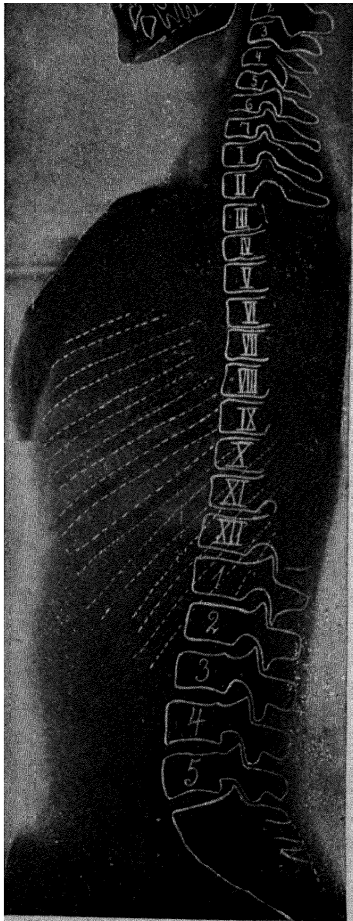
X-ray photo of a 12 years old boy (Fig. 88) standing erect. His back is sufficiently mobile to enable him to diminish the physiological curves not only of neck and loin but also of the dorsal spine.
